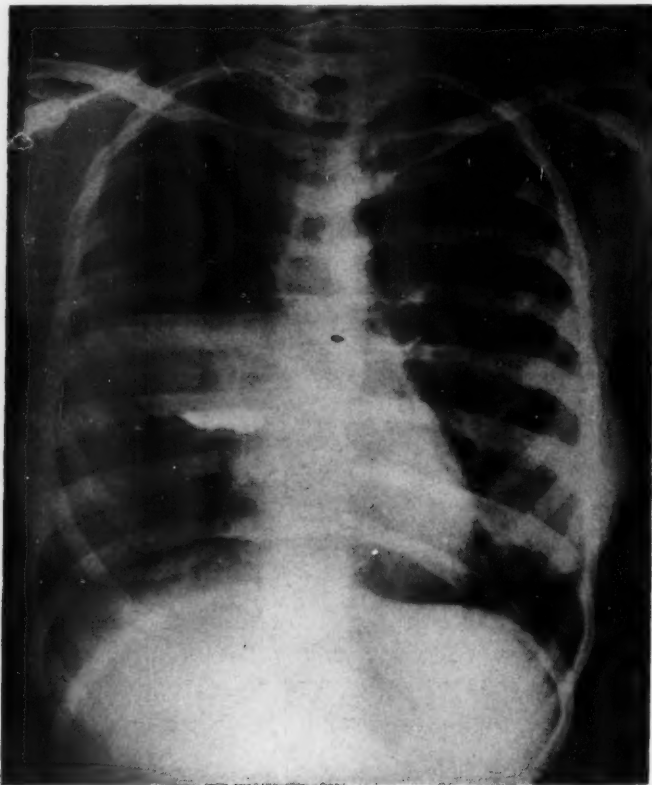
Case 4: Chest roentgenogram on admission, when a diagnosis of lung abscess was made.
